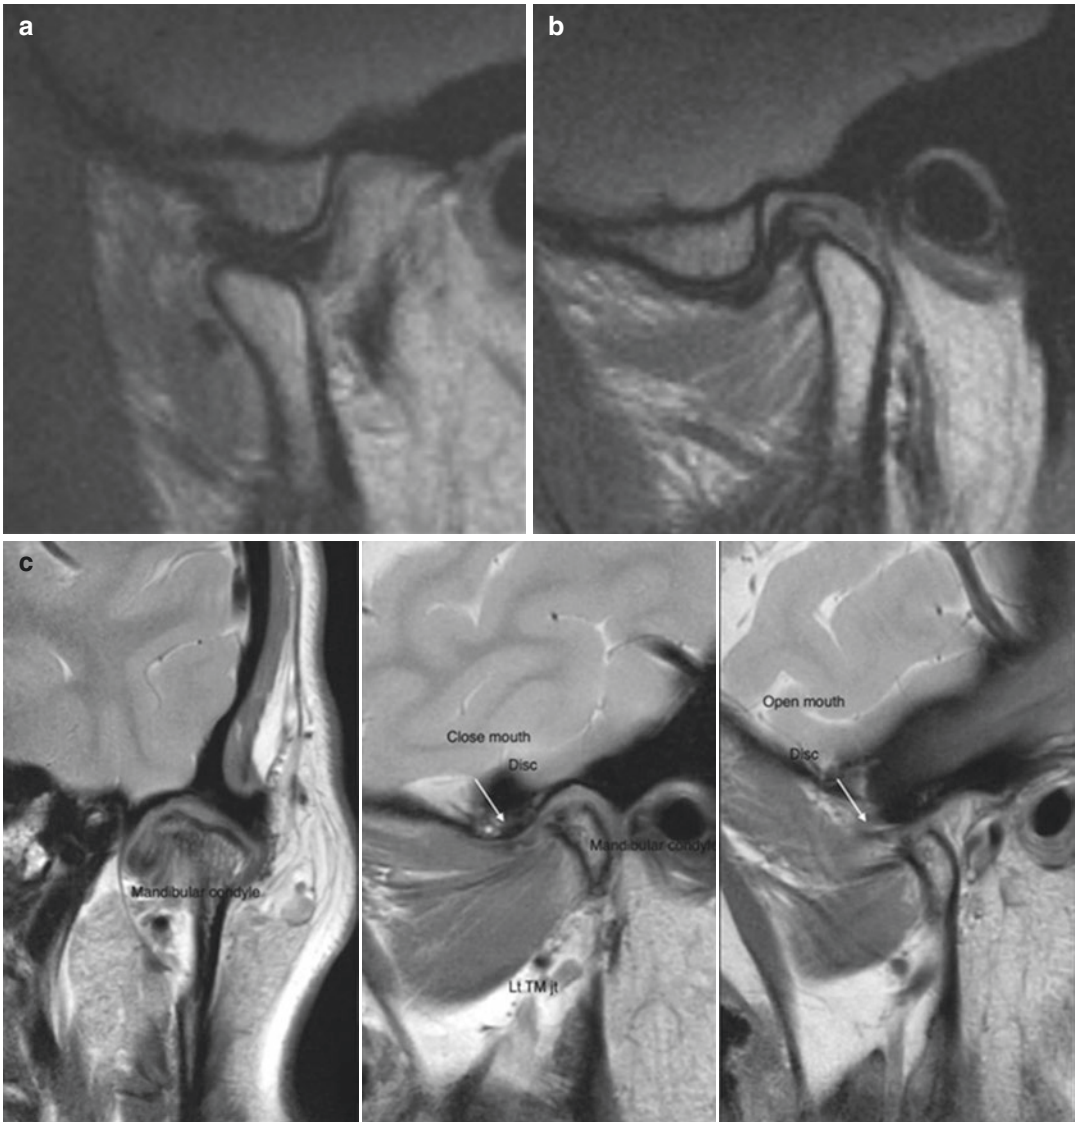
(a, b) MRI of joint with internal derangement. Axially-corrected sagittal T1-weighted MRI of the TMJ in the closed (a) and open (b) mouth position, respectively, exhibits anterior disc displaced with reduction. (Image courtesy: Dr. Dania Tamimi, USA, Diplomate of AAOMR). (c) Antero-medial disc location of the left TMJ
